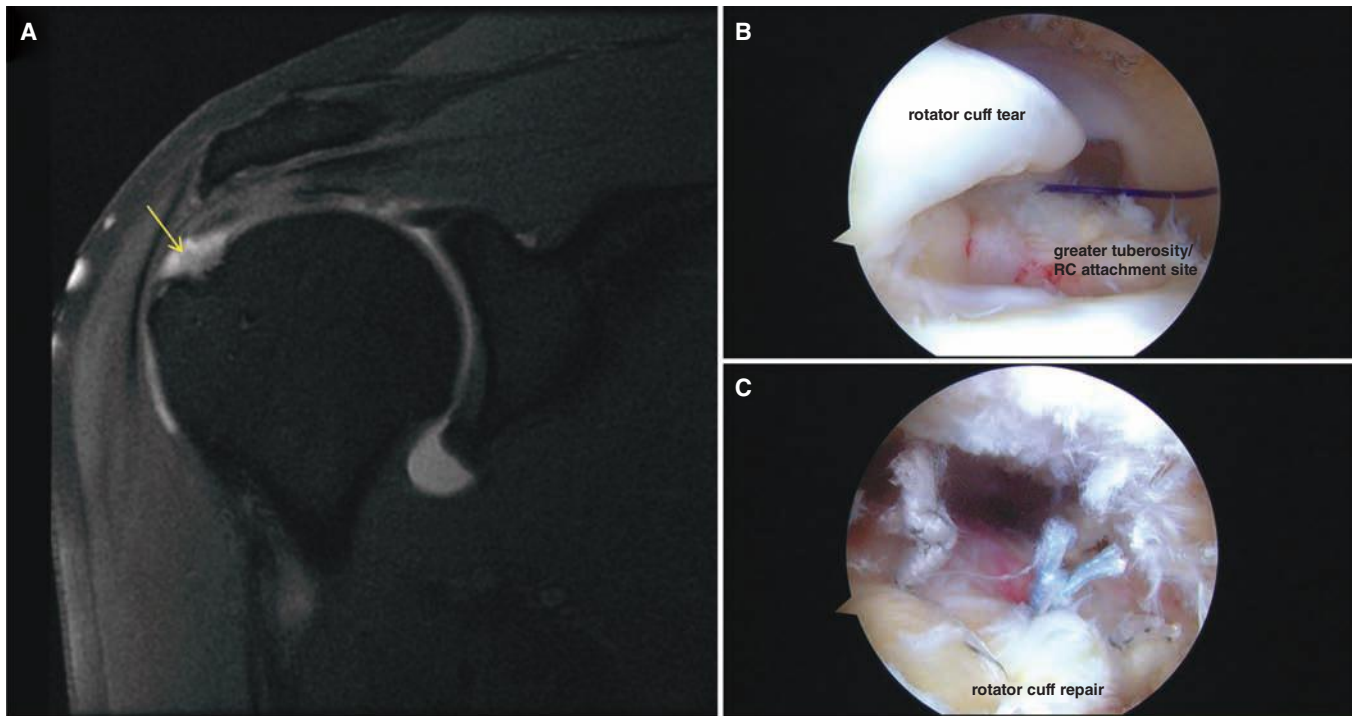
Imaging and treatment of rotator cuff tears. A. MRI coronal T2 image showing a full-thickness and moderately retracted tear (arrow) of the supraspinatus tendon. B. Arthroscopic image showing the supraspinatus tendon tear as viewed from a posterior portal during the surgery. C. Arthroscopic image showing completion of repair of the supraspinatus tendon tear using suture anchors imbedded in the greater tuberosity of the humerus and attached sutures that capture and reduce the torn tendon to its native insertion site.
